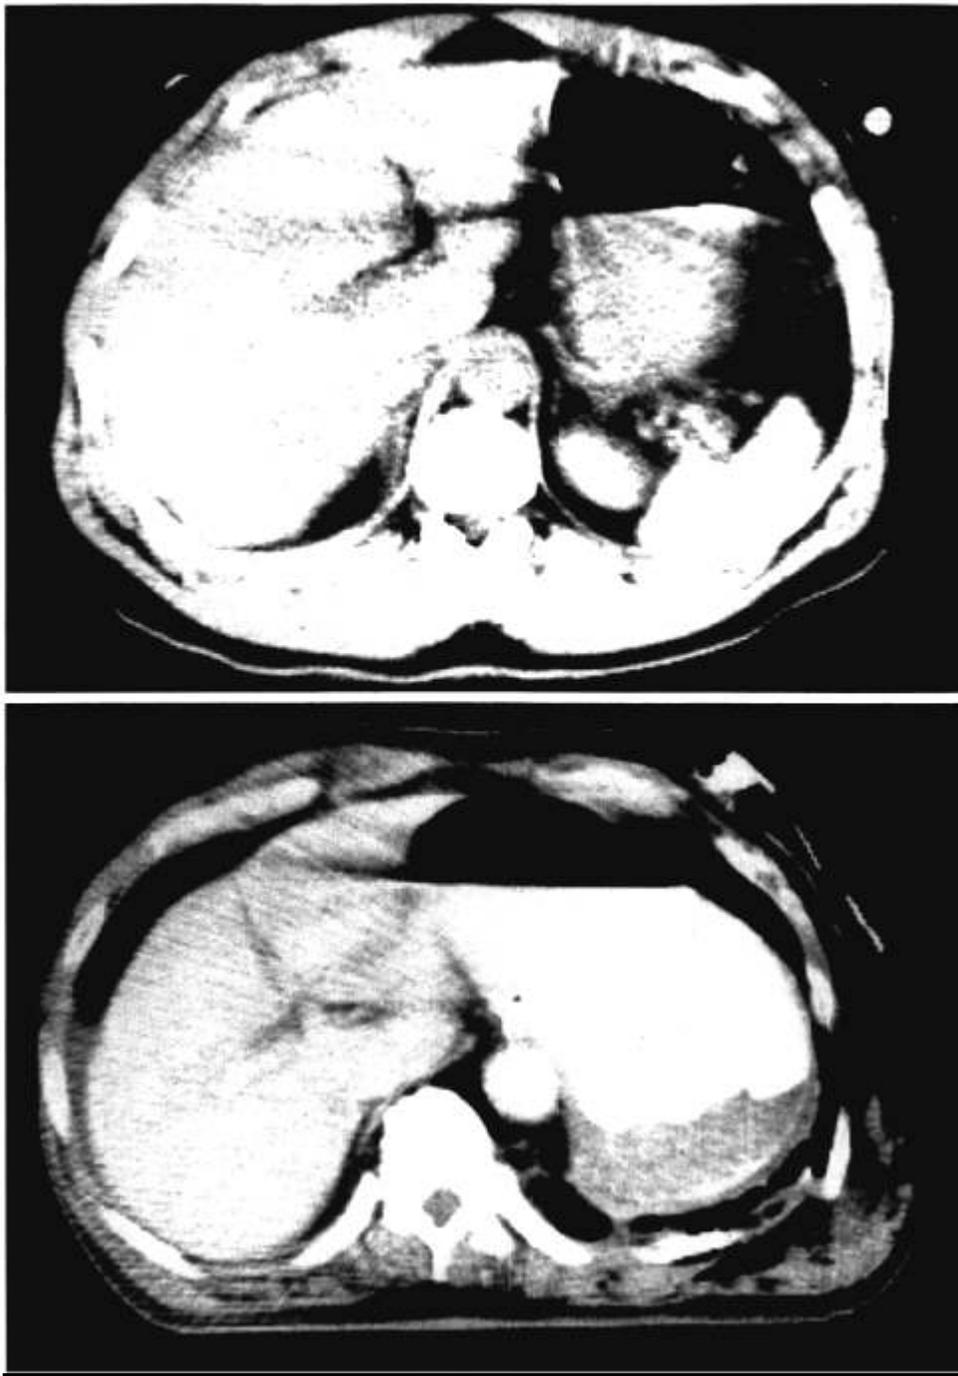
(Top) Falciform ligament injury obscured by artifact from air-fluid level in stomach. (Bottom) Falciform ligament injury classified as Grade 3 operatively and Grade 1 from CT scan.
